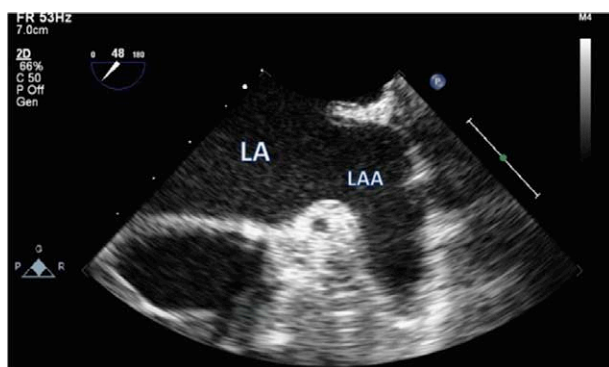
A baseline transesophageal image of the left atrial appendage before closure. LA indicates left atrium; and LAA, left atrial appendage.
